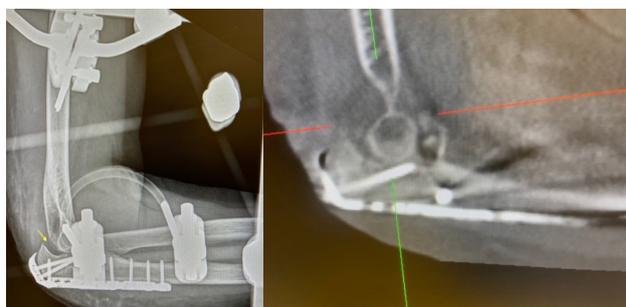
Postoperative X-ray and CT view after initial fixation. Despite the presence of hardware, ulnohumeral subluxation can be seen (yellow arrow) on the X-ray and escape of coronoid fragment on the CT.
